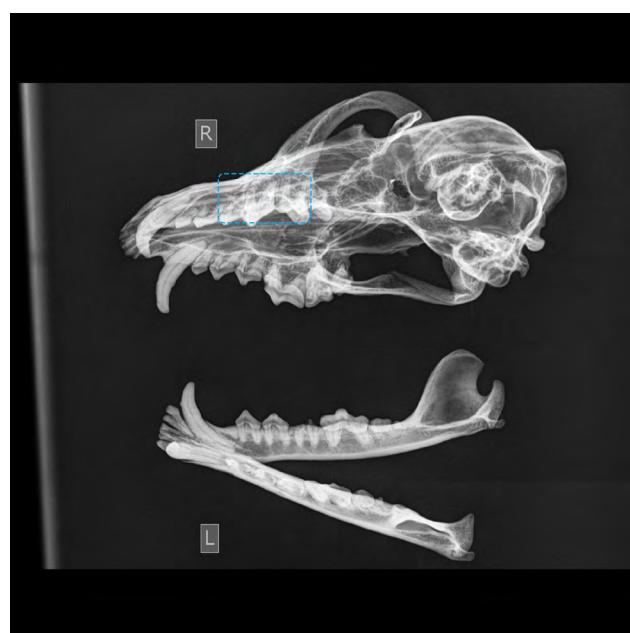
X-ray of the skull of the male red fox in Fig. 1 (periodontitis with local dehiscence – marked by a square).
